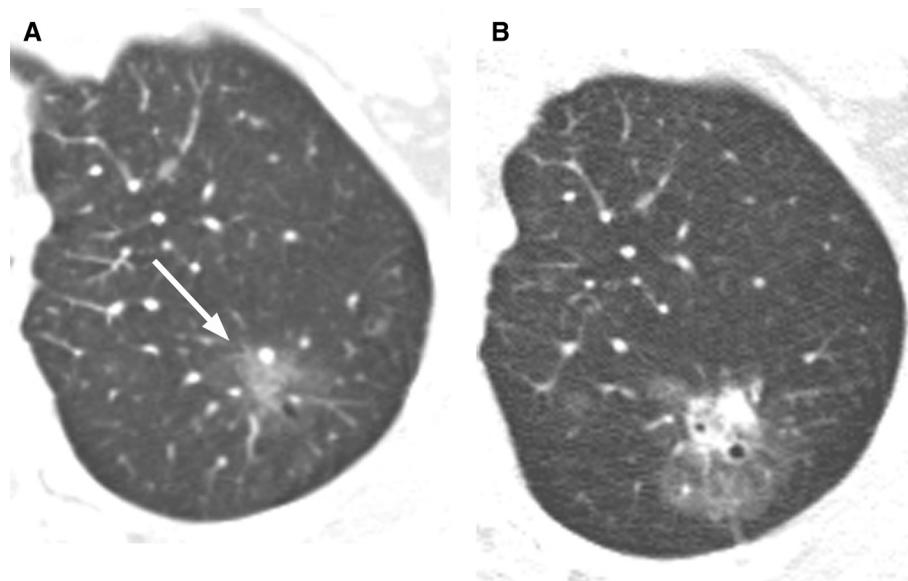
Subsolid nodule, demonstrating worrisome change. (A) An annual computed tomography (CT), demonstrating a persistent 14-mm pure ground-glass opacity (arrow). This is a Lung Reporting and Data System (LU-RADS) 4B nodule (likely low-grade adenocarcinoma). The patient was not referred to surgery and did not return for recommended follow-up. (B) CT 3 years later, showing the nodule has enlarged to 34 mm and contains a 12 mm solid portion. The nodule is now classified as LU-RADS 4C (likely malignant).
